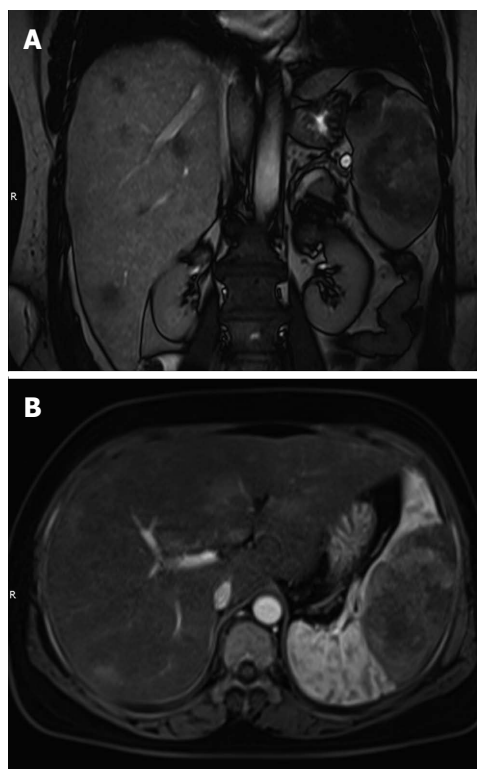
Magnetic resonance imaging. A: Coronal T2-weighted image revealed multiple nodular lesions in the liver parenchyma; B: Contrast-enhanced magnetic resonance imaging showed marked heterogeneous enhancement in the splenic mass, and multiple high signal intensity lesions in the liver.
